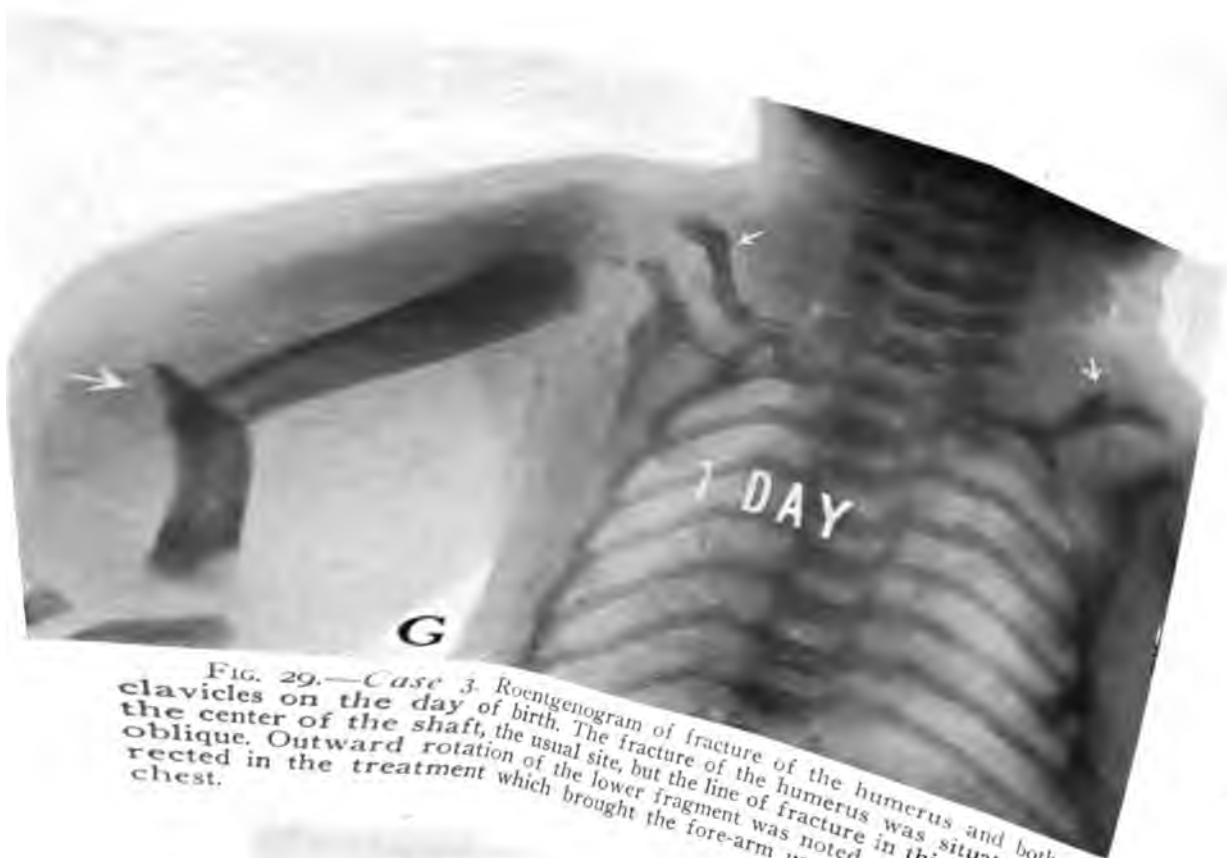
Case 3. Roentgenogram of fracture of the humerus and both clavicles on the day of birth. The fracture of the humerus was situated at the center of the shaft, the usual site, but the line of fracture in this case was oblique. Outward rotation of the lower fragment was noted, afterward corrected in the treatment which brought the fore-arm upon the front of the chest.
